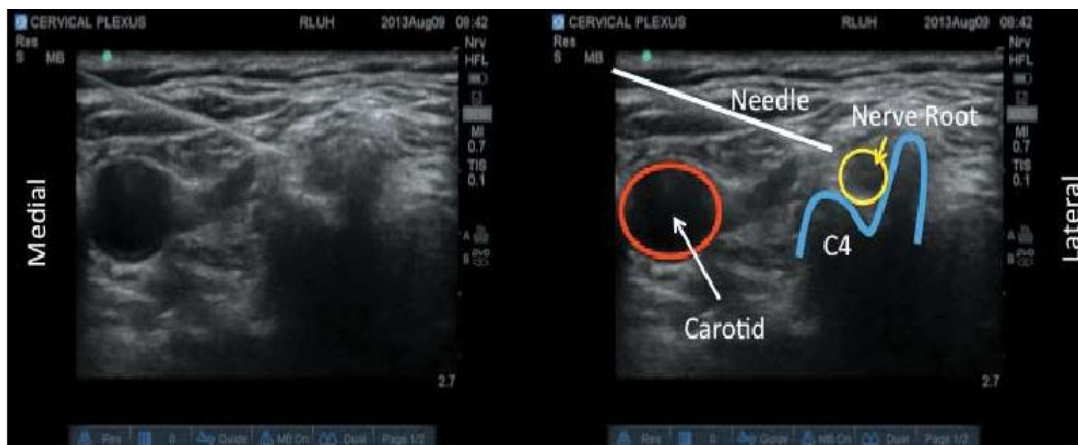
Ultrasound approach based on Winnie's description, LA is deposited between the scalenus anterior (SA) and medius (SM) at C4 level.
